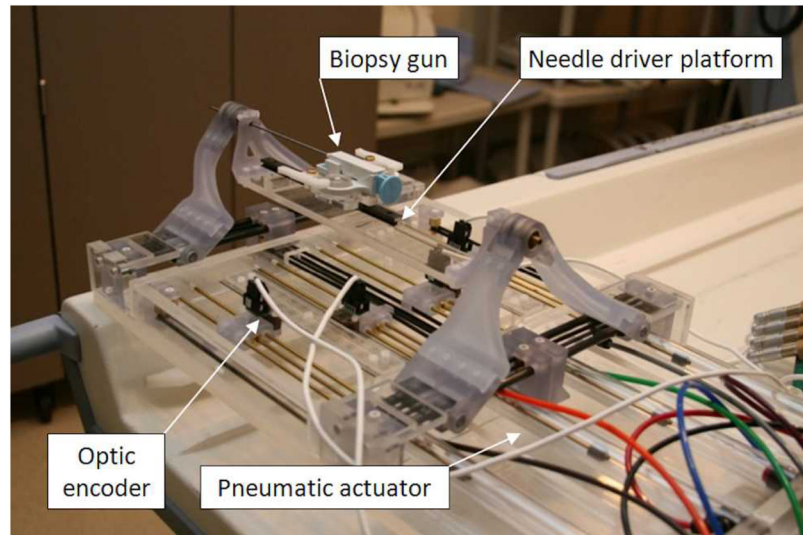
A photo of fabricated pneumatically actuated 4-DOF robot for MRI-guided transperineal prostate needle placement. A semi-automatic biopsy gun is located on needle platform
